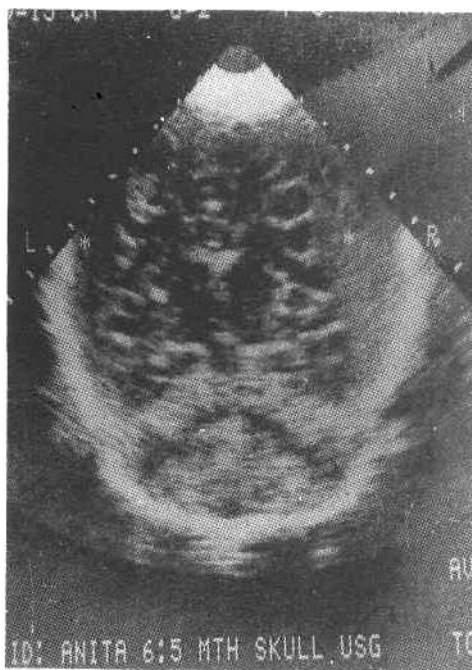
Coronal ultrasound scan showing bilateral subdural empyema (Right > Left).
